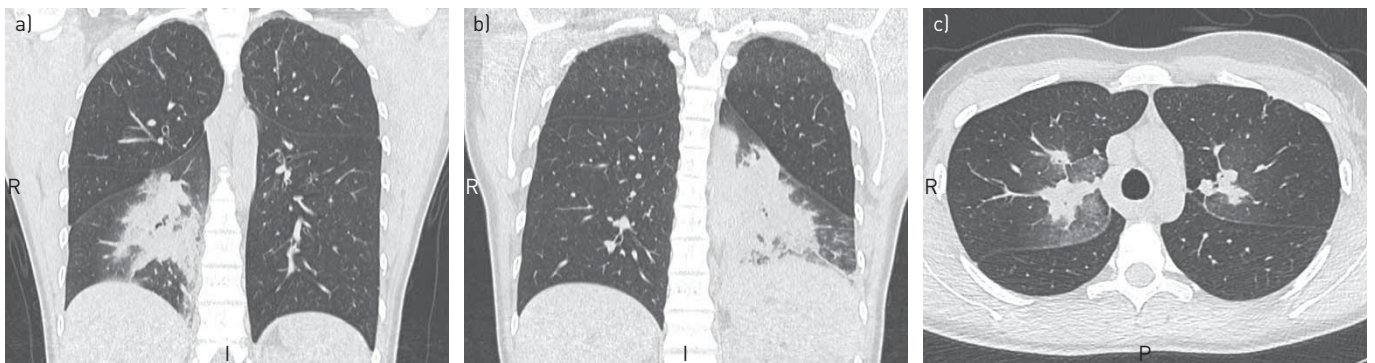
Chest computed tomography scans in the coronal plane the day after bronchial thermoplasty (BT) in a) the right lower lobe, showing peribronchovascular consolidations with bubble-like lucencies that completely disappeared 1 month later and b) the day after BT in the left lower lobe. Peribronchovascular consolidations are extensive and are associated with mild septal thickening and some lobar volume loss. c) Peribronchovascular opacities of limited extent are observed the day after BT in both upper lobes, which received the fewest number of activations. P: posterior; I: inferior; R: right.
